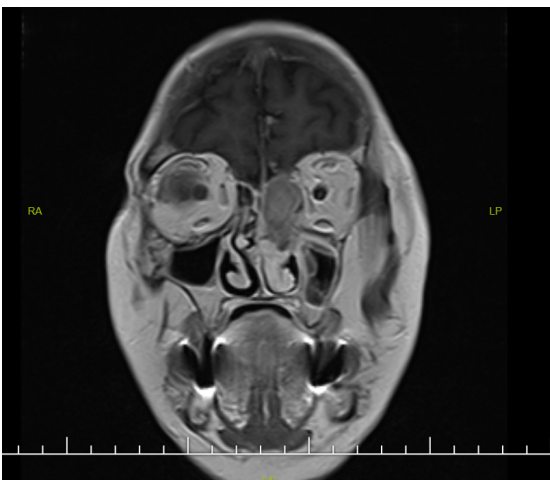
This orbital T1-weighted MR imaging scan of the coronal view shows a solid mass lesion measuring approximately 50x33x28 mm, with minimal compression in the medial rectus muscle, narrowing the optic canal; it is indistinguishable from the medial and inferior parts of the bilateral cavernous sinus
